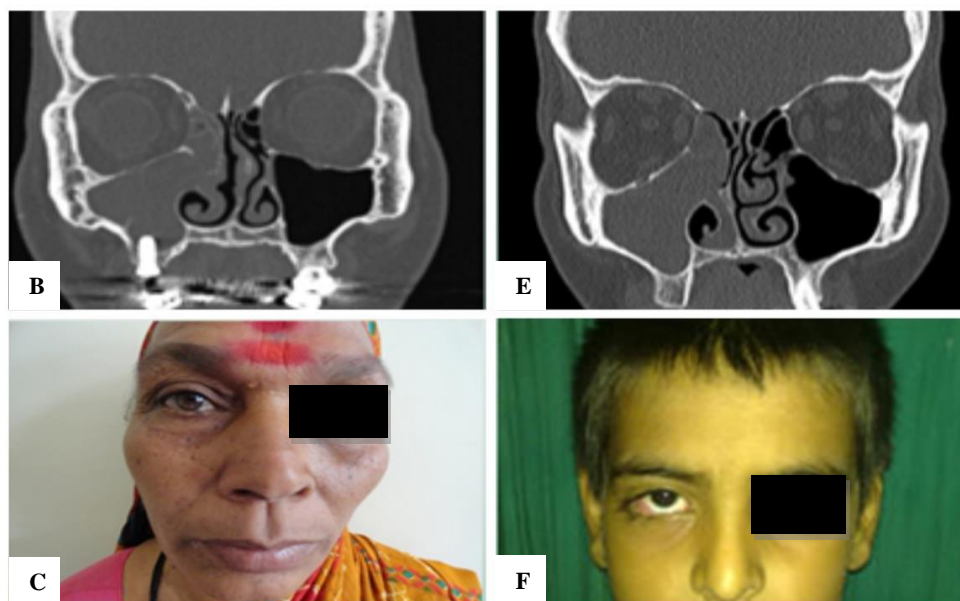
(B and E) CT of the patients showing orbital involvement with maxillary and ethmoid sinusitis; (C and F) Postoperative pictures of complete recovery of disease.
